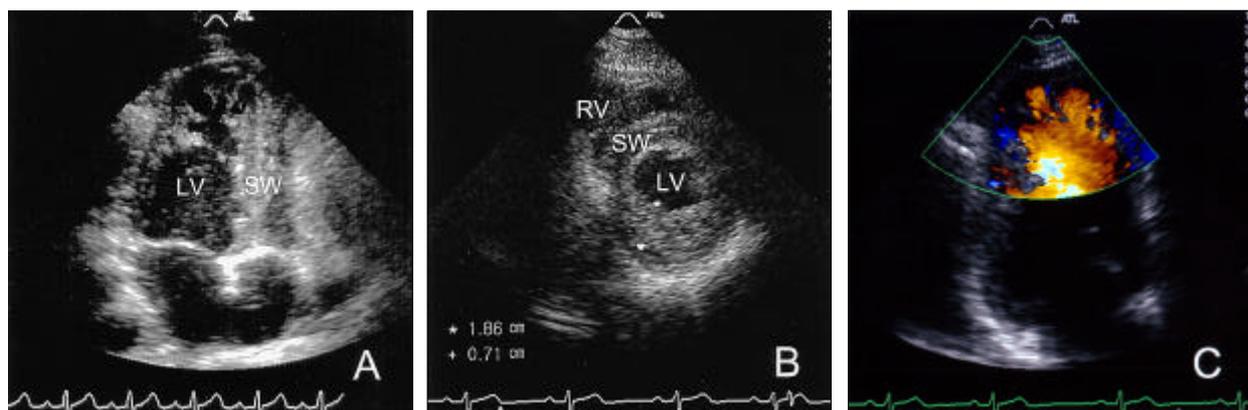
Transthoracic echocardiogram (TTE) of the proband. (A) Apical 4-chamber view shows prominent left ventricular trabeculations with multiple deep intertrabecular recesses. (B) Parasternal short axis view shows a thin compacted epicardial layer and a thickened endocardial layer at end systole. (C) Color-flow imaging shows communication between intertrabecular spaces and the left ventricular cavity. LV, left ventricle; RV, right ventricle; SW, septum wall.
